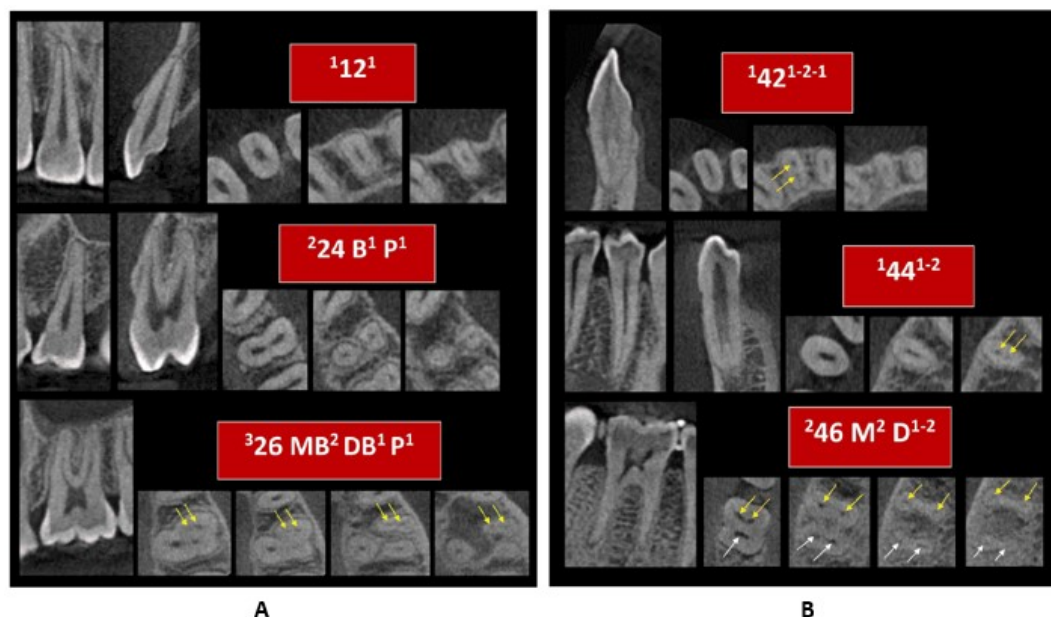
Examples of Ahmed et al. classifications in maxillary teeth (A) and mandibular teeth (B) in CBCT scans¹⁴
